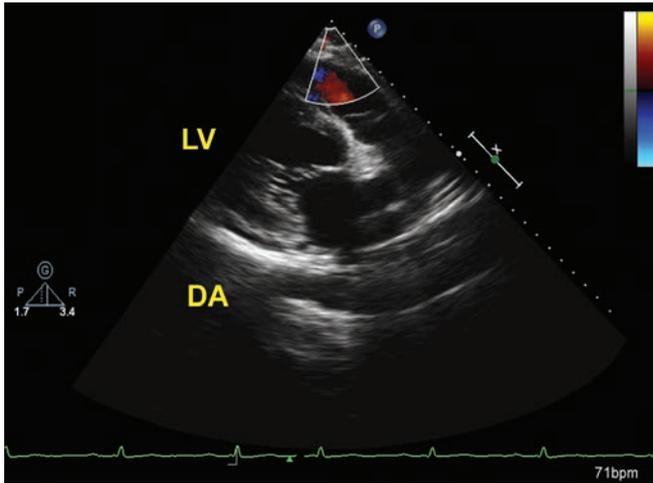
Descending thoracic aorta (DA) viewed in long axis in the LV-pulmonic plane (modified parasternal short axis view).
